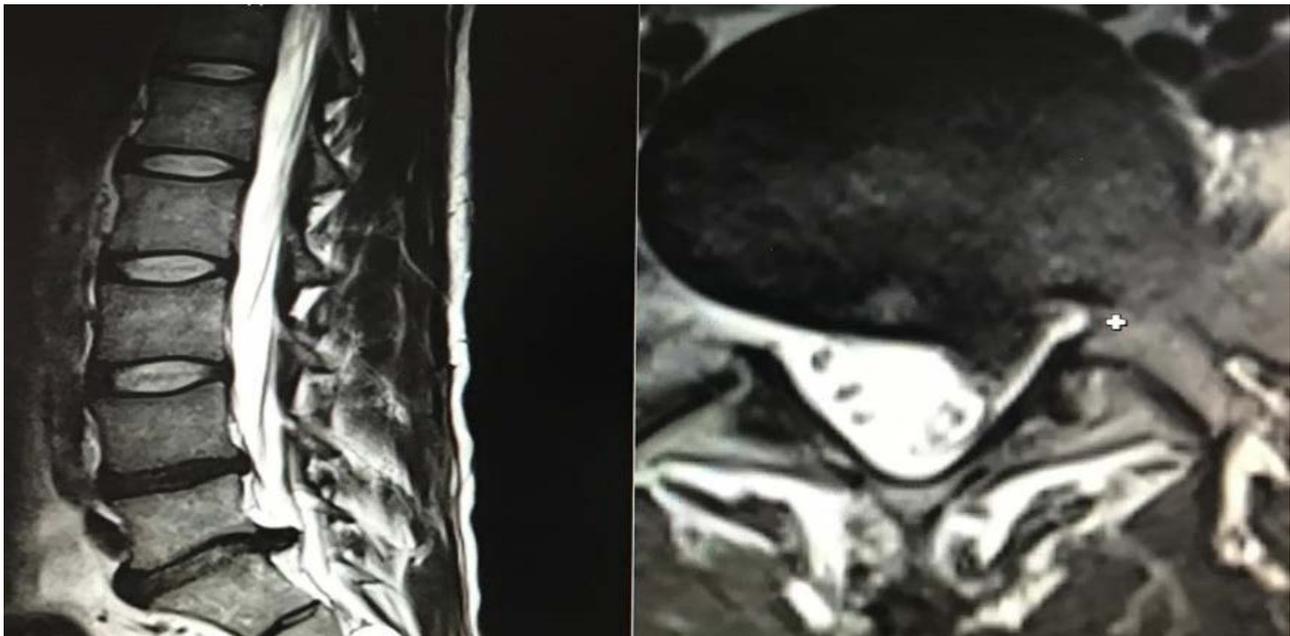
32-year-old male patient. MR images of the patient who was scheduled to undergo endoscopic discectomy using the Destandau technique for a lumbar disc herniation (left paracentral extruded disc herniation at L5-S1 level).
